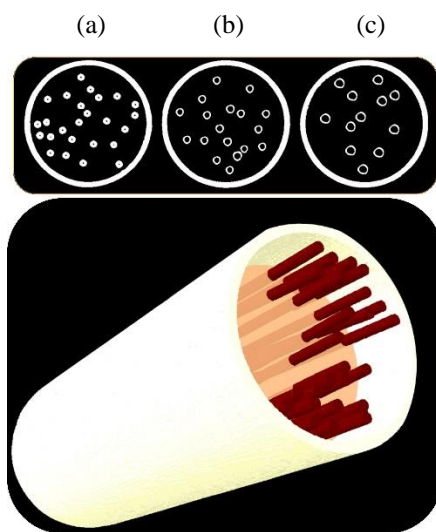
CT scans of the capillaries in a 13 mm tube. Upper panel – 2D images: Tapered capillaries with inner diameter of (a) 510 μm (b) 600 μm and (c) 750 μm . Lower panel – 3D image where tapered capillaries have an inner diameter of 510 μm .
